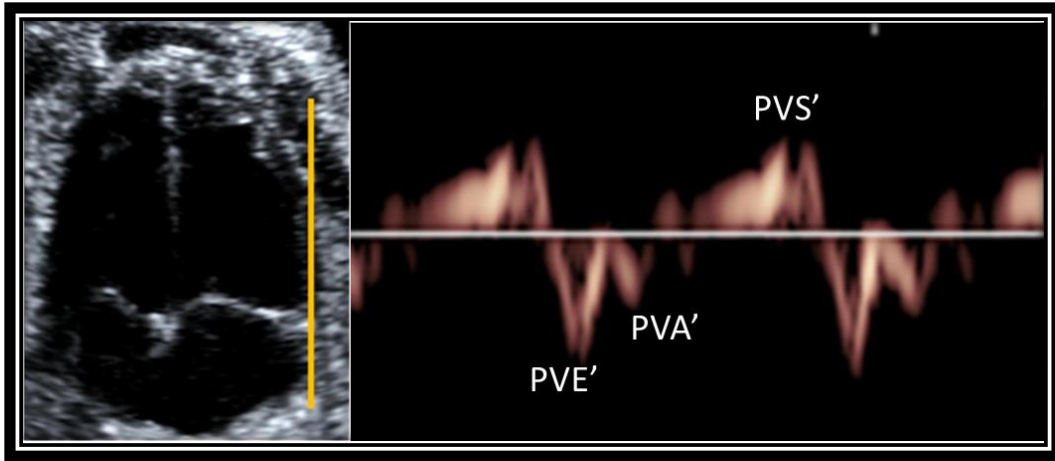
Example of an early (E') and late (A') diastolic and systolic (S') peak annular velocities obtained by spectral tissue Doppler at the right annulus.
